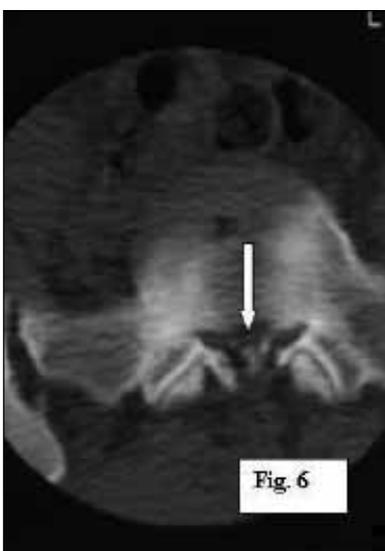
CT of case 17: CT demonstrated subtotal obstruction due to a calcified central herniated nucleus pulposus into the spinal canal at the L5-S1 level (arrow).
